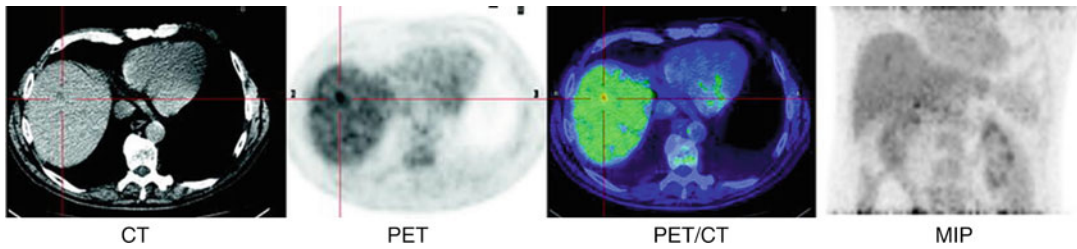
Patient treated for primary colorectal cancer and referred for restaging. [^{18}F]FDG-PET/CT scan identified unexpected metastases in the liver not seen at CECT
